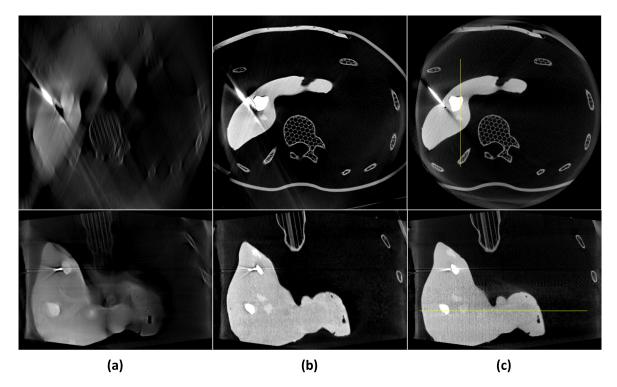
Reconstruction results. (a) zero-initialized ART, (b) proposed method (prior-initialized ART), and (c) intraoperative CBCT. Upper row: one axial slice. Lower row: one coronal slice. Same slices are shown in (a), (b), and (c). The display window range is [-1000HU, 700HU].
